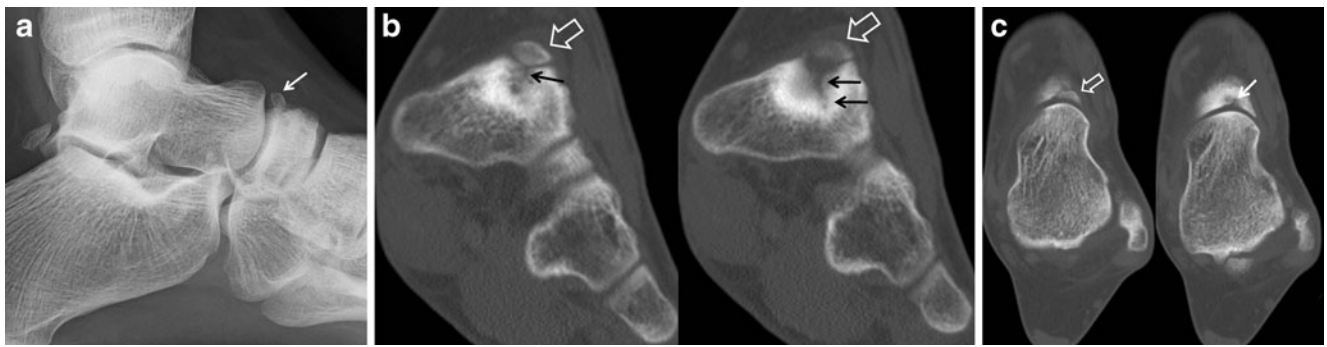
a Lateral radiograph of the foot demonstrates a well-corticated ossicle dorsal to the proximal aspect of the navicular bone, consistent with an os supranaviculare. No convincing findings of a navicular stress fracture were identified. b Successive coronal CT images of the mid-foot in the same patient show a well-corticated ossicle (*open white arrow*) at the dorsal margin of the proximal navicular bone situated within an osseous depression. A sagittally orientated fracture
